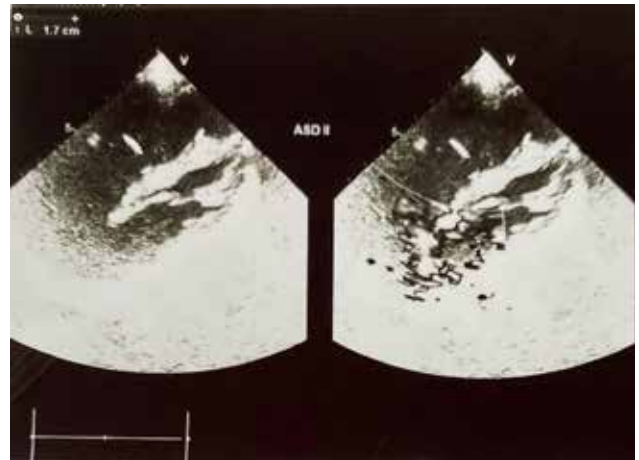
Echocardiography showing the ostium secundum ASD (Diameter 1.7 cm)
